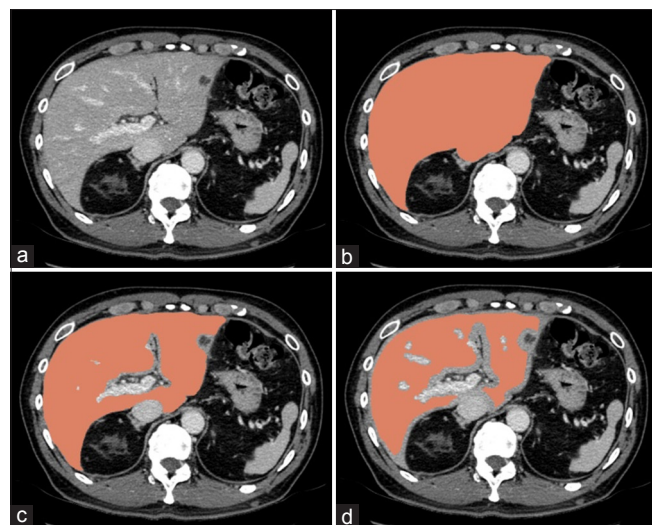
Example of delineation of regions of interest (ROIs). (a) computed tomography images. (b) ROIs (the red region) of the entire three-dimensional liver volume. (c) ROIs with liver parenchyma excluding the lesions, main portal vein, and other structures. (d) Final ROIs after 3 mm of shrinkage.
